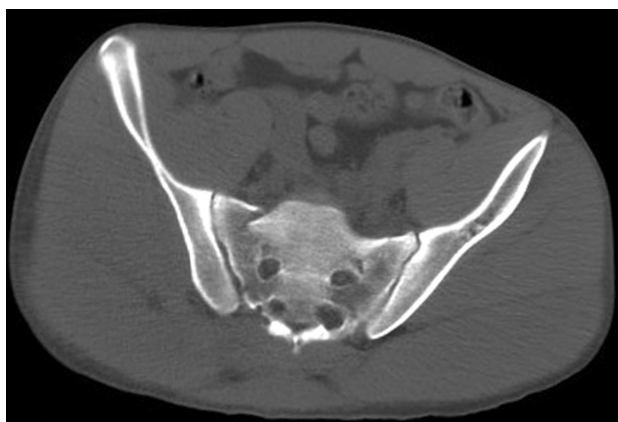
Sacrum CT image. Note displaced fracture of the right sacrum.
